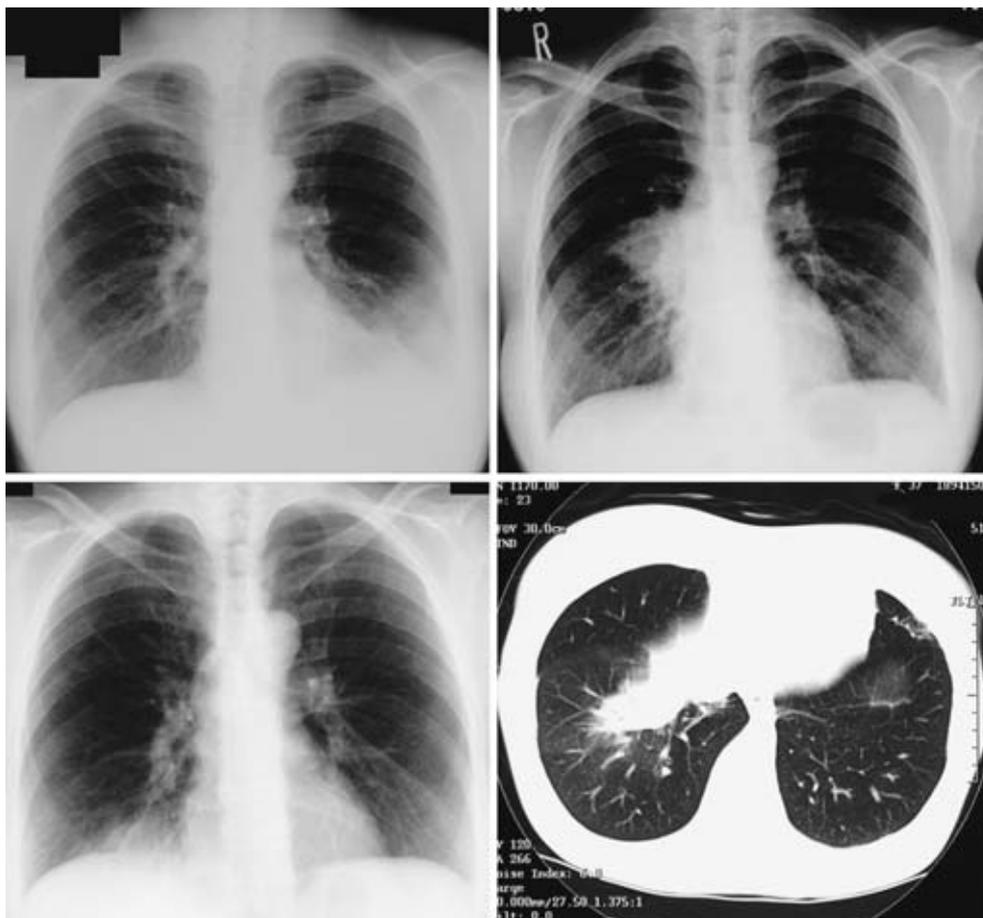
A chest radiograph taken on April 18, 2002 shows an infiltrative shadow in the left lower lobe (upper left). A chest radiograph taken on June 22, 2003 shows an infiltrative shadow in the right middle lobe (upper right). A chest radiograph taken on admission (November 22, 2003) shows an infiltrative shadow in the left lower lobe (lower left). A chest CT taken on November 25, 2003 shows ground-glass attenuation around the infiltrative shadow in the right lower lobe (S⁸) (lower right).
